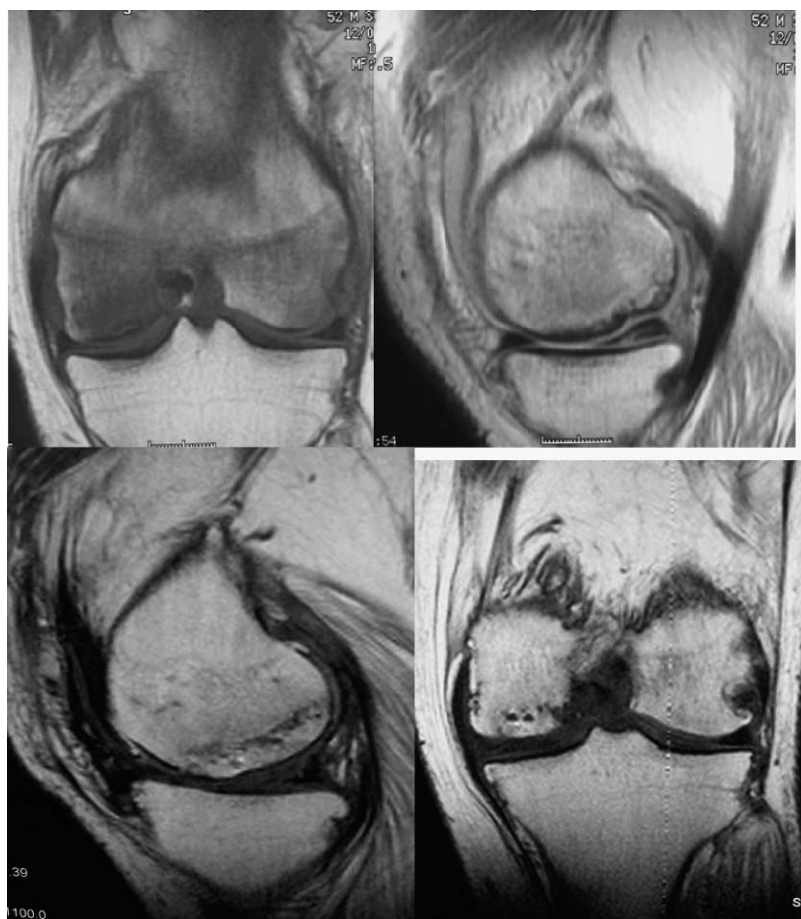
Nuclear MRI in which the osteochondral defect in the internal femoral head (CFI, for its initials in Spanish) and the meniscal tear can be seen in the top pictures. Nuclear MRI at 8 months following surgery in the bottom pictures.
